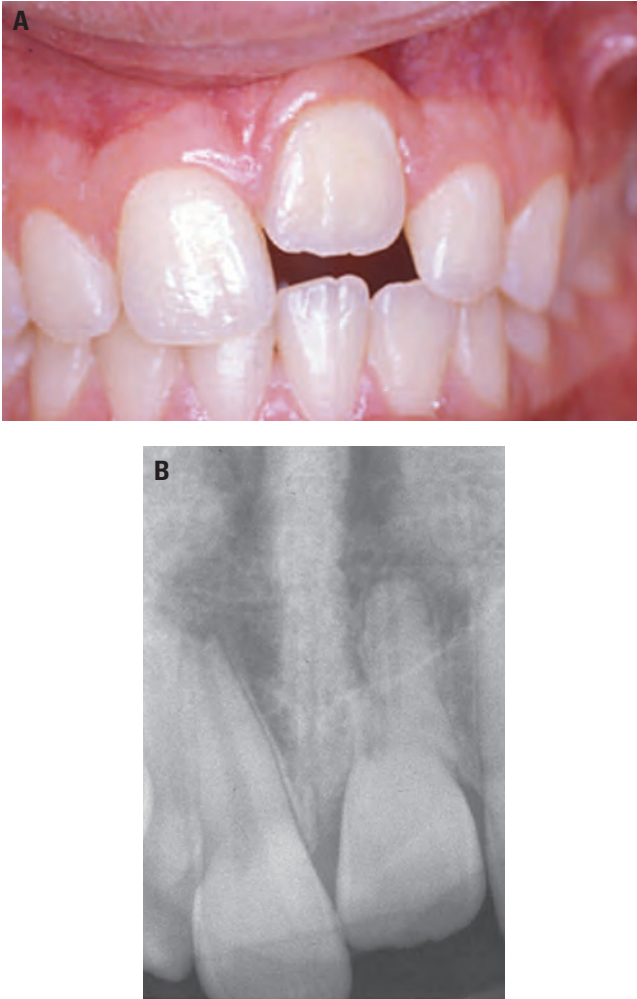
Ankylosis-related resorption, also called replacement resorption. A, Photograph shows tooth no. 9 in an infra-occlusal position as a result of trauma at an early age, causing the tooth to be ankylosed. B, Radiograph shows replacement of the root with bone, resulting in ankylosis.
